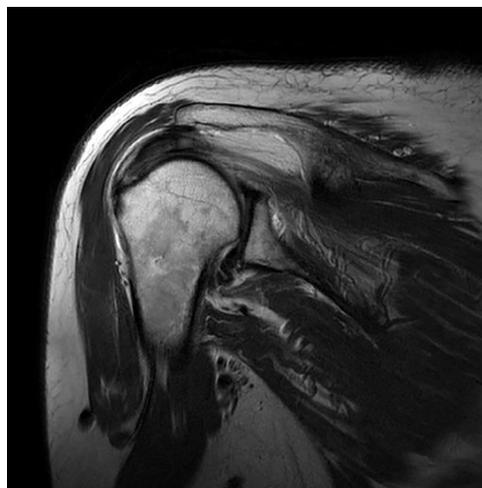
Heel-type osteophyte. The inferior bony projection of the acromion anterolateral undersurface on a T2 coronal view magnetic resonance image looks like the heel of a shoe.
